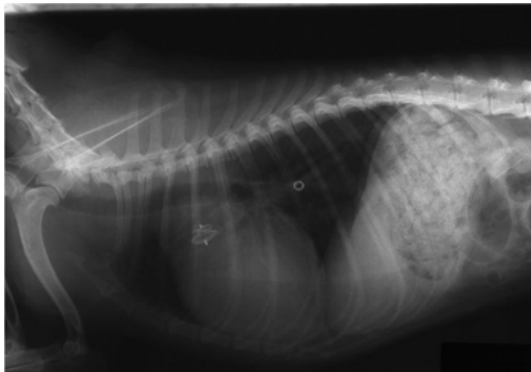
Thoracic radiography taken after the occlusion using a ductal occluder. The occlude was successfully placed at ductus arteriosus, but reverse positioning.
